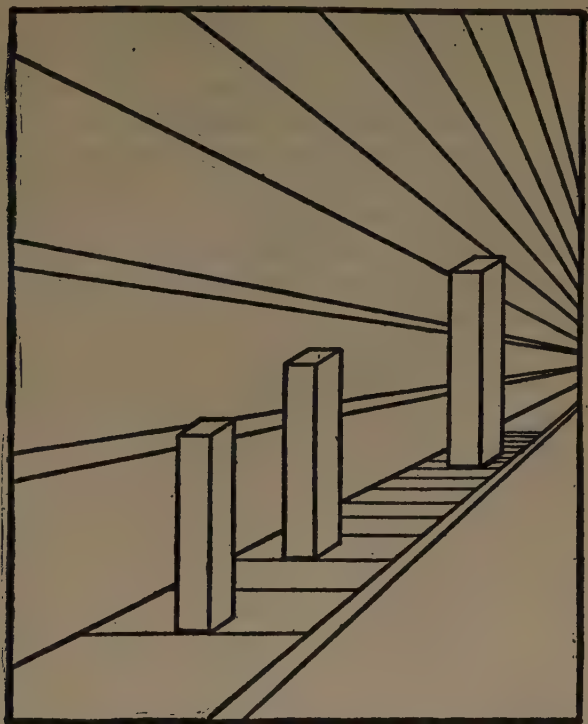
DECEPTIVE APPEARANCE OF SIZE THROUGH THE SUGGESTION OF PERSPECTIVE LINES.
